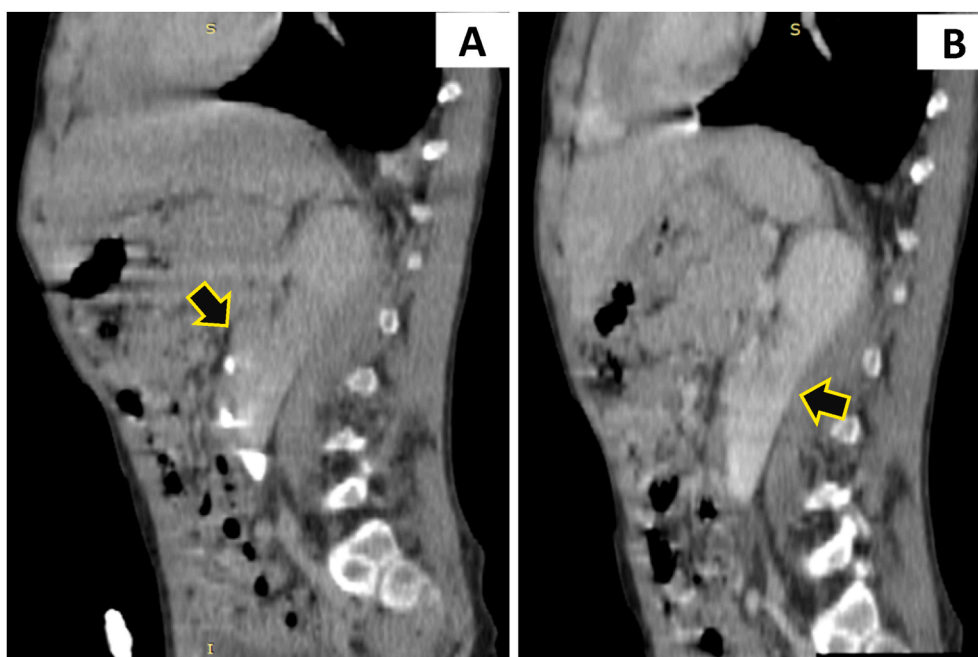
(A): is a sagittal CT scan with delayed venous phase. (B) is a sagittal CT scan with venous phase, showing a crossed fused ectopic left kidney (arrows).
